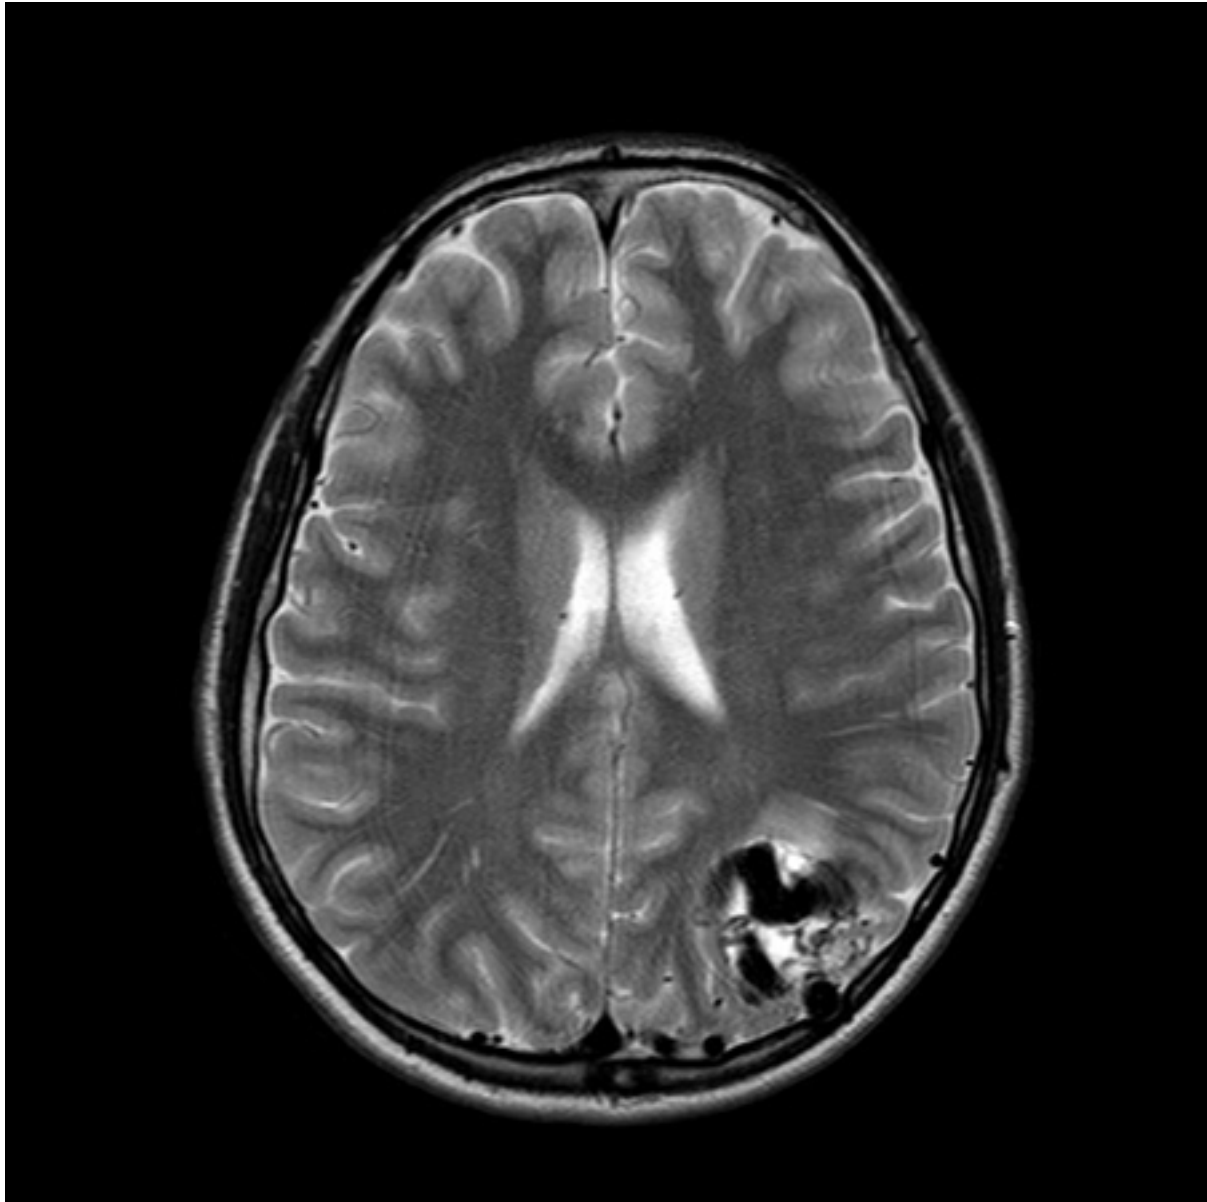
Unruptured left parieto-occipital AVM (axial T2-weighted MRI scan)
